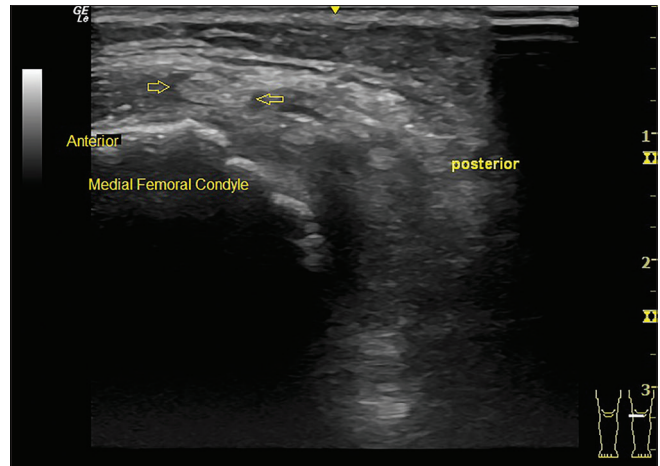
Transverse ultrasound of the left gracilis tendon at the medial condyle – Case 2, a 72-year-old female with prior left total knee arthroplasty and painful snapping of the medial knee. The gracilis tendon in knee flexion before snapping over the medial femoral condyle seen as a hyperechoic oval structure. Left side of the picture is anterior; right side is posterior. Arrows denote the gracilis tendon.
